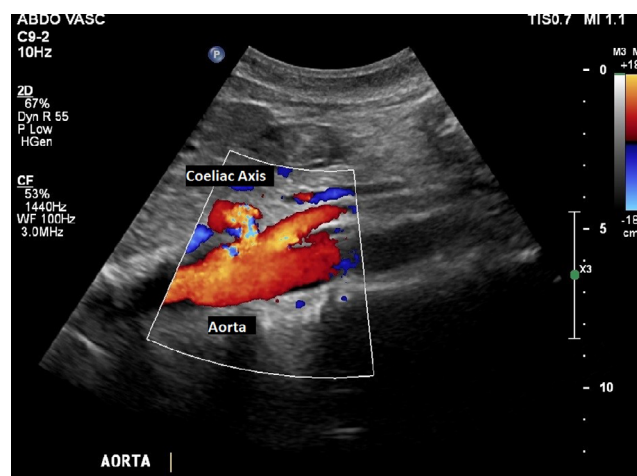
Colour Doppler of the Coeliac Axis Origin.
